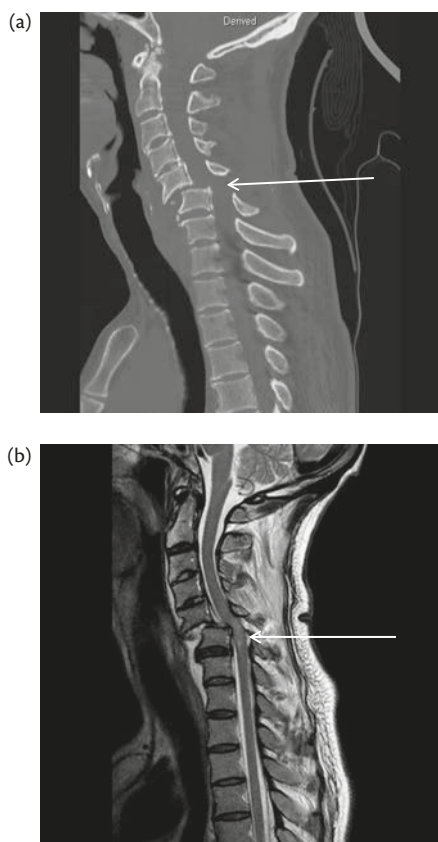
(a) Sagittal CT image showing anterolisthesis of C5 on C6 (arrow) secondary to bilateral facet joint dislocation (arrow). (b) T2-weighted MRI image of same injury with signal change in the spinal cord (arrow) and disruption of anterior and posterior longitudinal ligaments.
